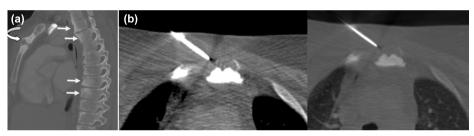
(A) Sagittal CT of the chest shows the diffuse sclerotic changes of the sternum (arrow) and patchy sclerosis of the thoracic spine (arrowheads) mimicking osteoblastic breast metastases. Note the sclerotic changes predominantly involve the anterior aspect of the thoracic spine and multiple contiguous levels. (B) Axial CT of the sternum at the time of the biopsy.
